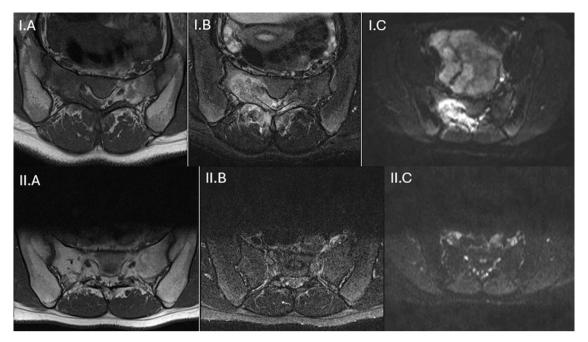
I: Lumbosacral MRI at diagnosis. Axial slice at S1, sequences I.A) T1, I.B) STIR, I.C) DWI. II: Lumbosacral MRI after three months of antibiotic therapy. Axial slice at S1, sequences II.A) T1, II.B) STIR, II.C) DWI. T1: longitudinal relaxation time; STIR: Short time inversion recovery; DWI: Diffusion-weighted Image.
